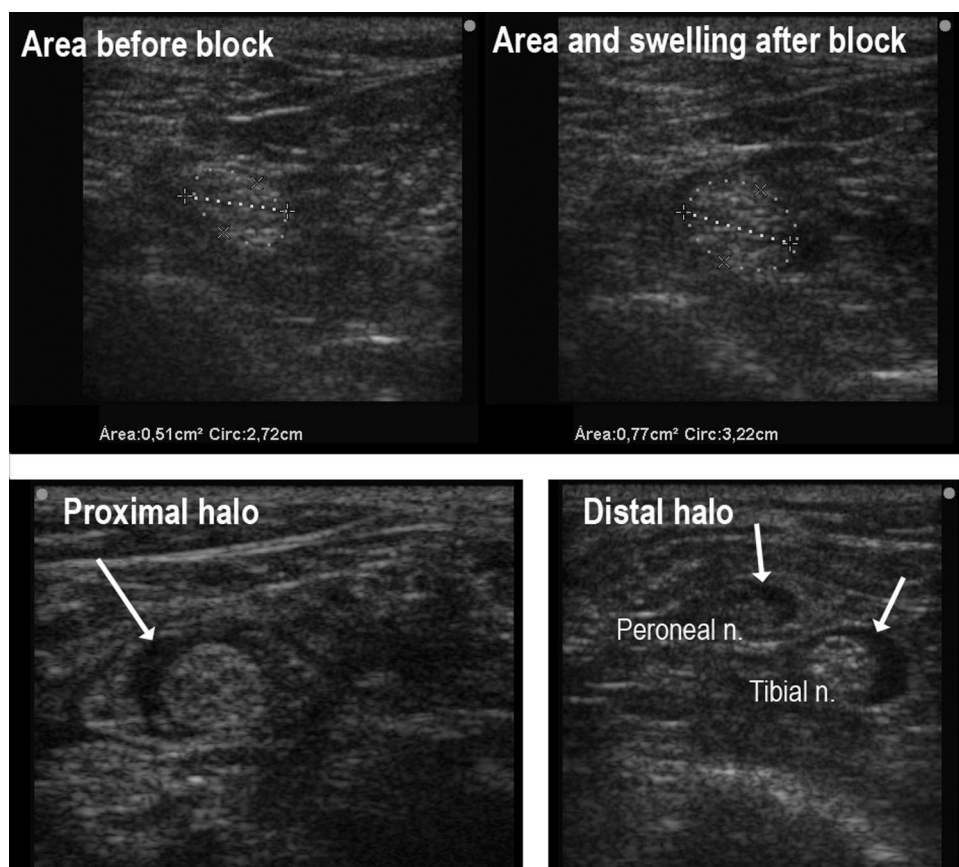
Ultrasound signs used to define intraneural injection criteria. Ultrasound images demonstrate increased sciatic popliteal nerve dimensions after the block and proximal and distal diffusion of local anesthetic following the path of the nerve and its two divisions (arrows).
